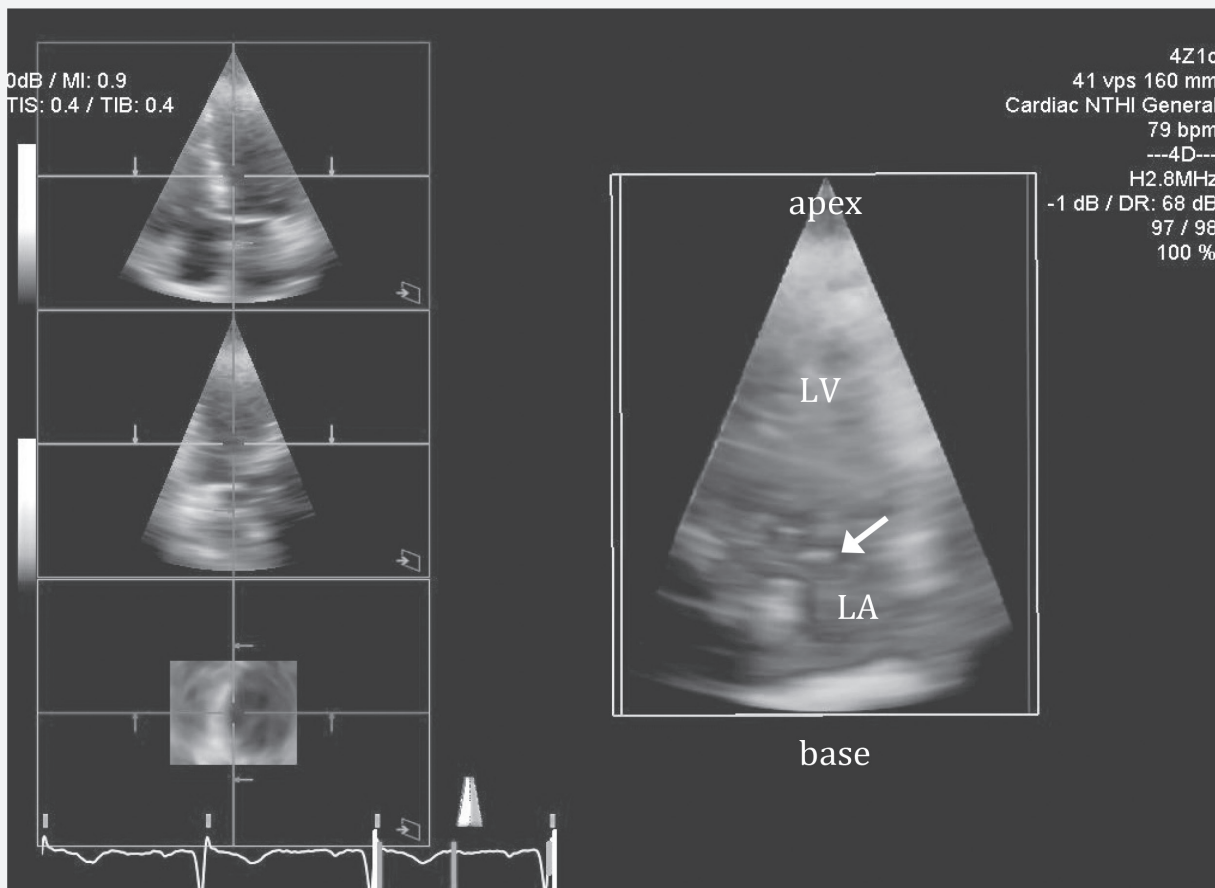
Transthoracic 3D echocardiography showing an en-face view of the primum ASD (arrow) from a left atrial perspective. Abbreviations: 3D, three-dimensional; ASD, atrial septal defect; LA, left atrium; LV, left ventricle.
